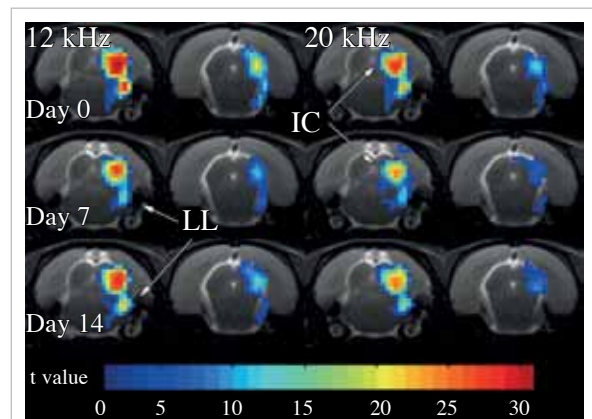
Functional magnetic resonance imaging showing the mean t-value maps immediately after 15 minutes of exposure to 100-dB sound pressure level noise (day 0), 7 days after exposure (day 7), and 14 days after exposure (day 14). Activation maps acquired with 12-kHz and 20-kHz noise stimulation are overlaid on anatomical images. Activation is mainly observed in the inferior colliculus (IC) and lateral lemniscus (LL) in the hemisphere contralateral to the stimulated left ear.
